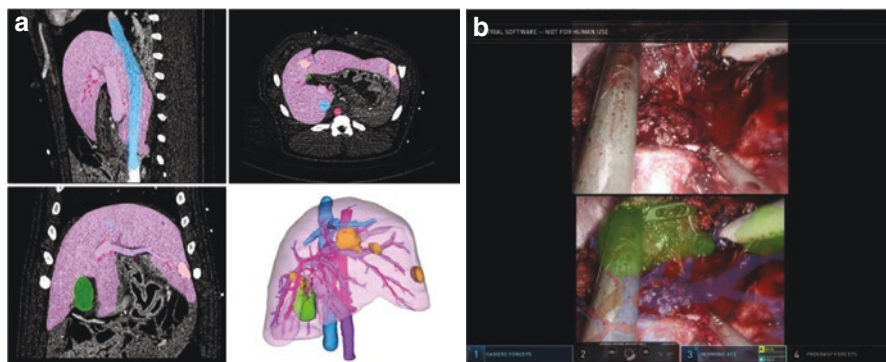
Real-time navigation. (a) Interactive 3D PDFs generated from CT/MR DICOMs. (b) Real-time overlay of PDF onto console TilePro
